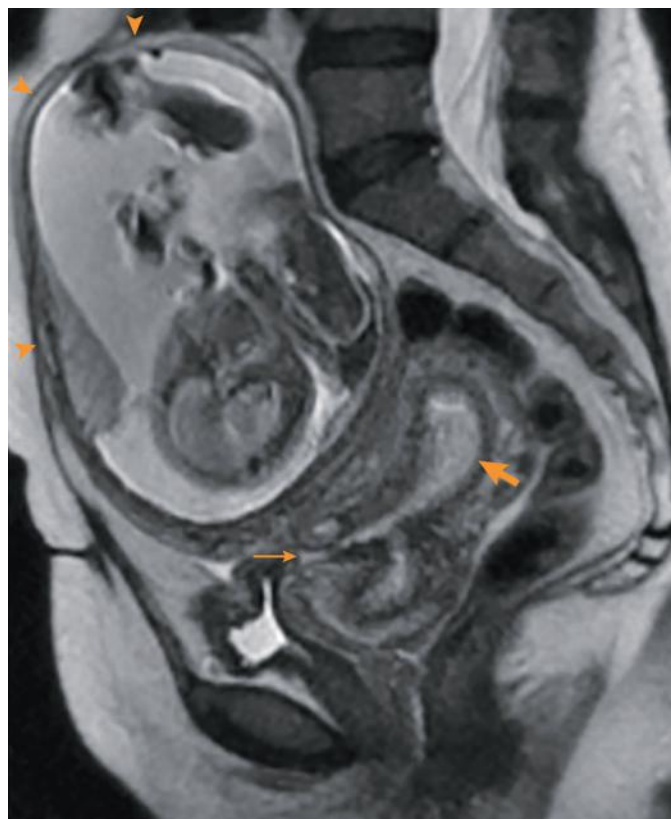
Rudimentary horn ectopic pregnancy at 19 weeks' gestation. Sagittal T2-weighted imaging demonstrates ectopic pregnancy implanted within a noncommunicating rudimentary horn of an anomalous uterus (*arrowheads*). The unicornuate endometrial cavity is empty (*bold arrow*) and there is a previous cesarean scar (*small arrow*).
